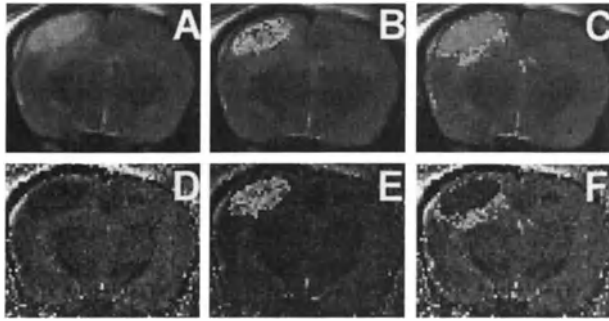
T2-weighted image (A) and ADC-map (D), 90 min after trauma, used for generating the histogram in Fig. 1 Image (D) shows a region of decreased signal intensity indicating the predominant cytotoxic edema component. Core-region (B, E) and edema-rim (C, F) segmented out of the histogram, are high lighted in both images
